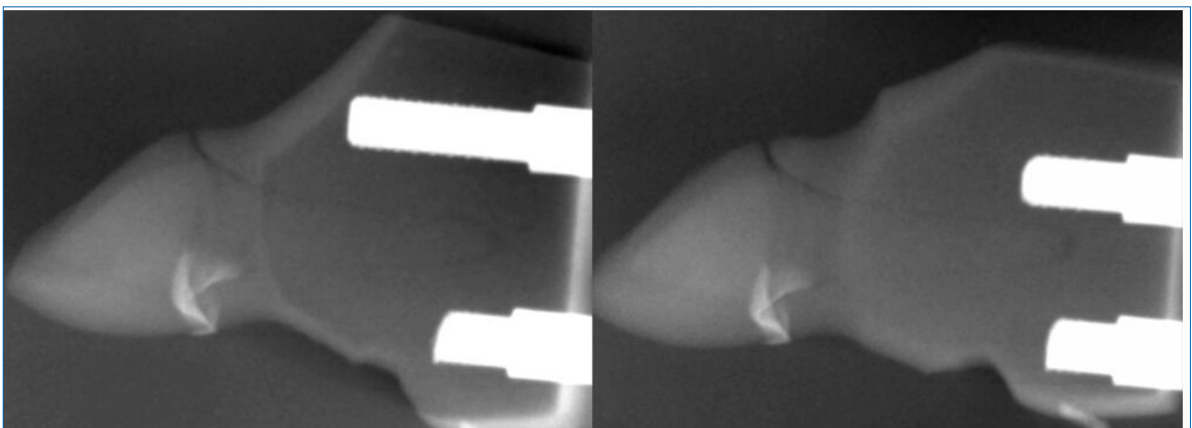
Endorsal x-rays that shows the space between posts and dies (Left: DRS impression, Right: traditional impression)
